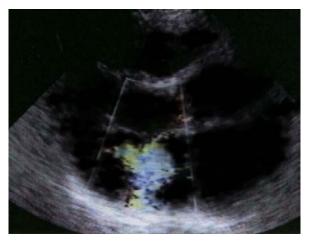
Parasternal long axis view of the left ventricle in a patient one year after Q (+) posterior myocardial infarction. Mitral regurgitation is recorded - in the cavity of the left atrium, a blue-colored flow is determined at the time of left ventricular systole.
